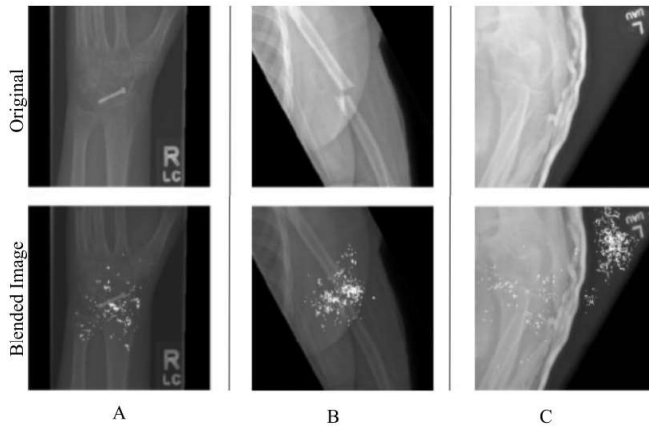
In Column A, the original image contains hardware in the wrist region which the blended saliency map accurately isolates. In Column B, the original image contains a fracture in the humerus which is also isolated by the saliency map. In Column C, the saliency map highlights arbitrary gray space in the radiograph, which is irrelevant to the task of abnormality detection.
